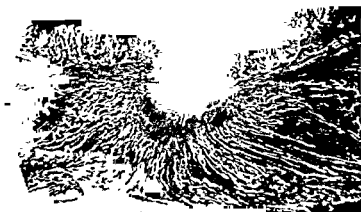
Radiograph of vessels of lesser curve ulcer of 5-6 months' duration. Normal pattern of arteries and veins in submucosa is lost and replaced by venules radiating from ulcer and extending across full width of lesser curve. Transverse section across lesser curve, 400 μ thick. ($\times 4$.)
